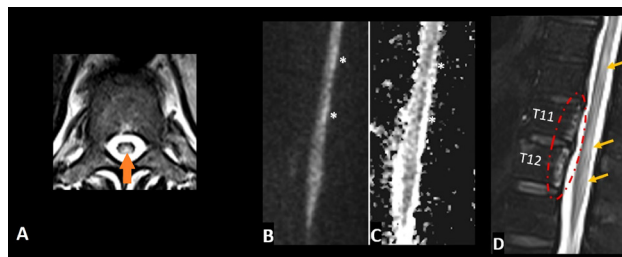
Thoracic spine MRI images – axial T2-weighted (Figure A), sagittal diffusion-weighted (Figure B), ADC map (Figure C), and sagittal STIR (Figure D) sequences. T2 hyperintensity in the posterior columns of the lower thoracic spinal cord (orange arrows) and conus medullaris, with restricted diffusion (white asterisks). STIR hyperintensity is observed in the posterior wall of the T11 and T12 vertebral bodies (dashed red circle), suggesting bone infarction, which is a confirmatory sign of spinal cord infarction in this context.
